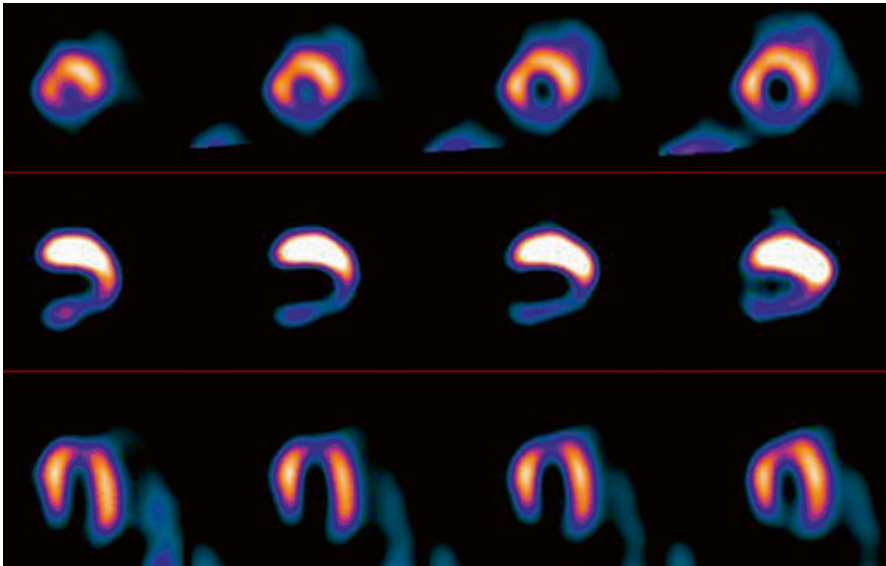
[^{123}I]-MIBG SPECT in a 43-year-old male HD patient. Note the low activity within the inferior left ventricular wall. Low [^{123}I]-MIBG inferior wall uptake that is often seen in SPECT can be an effect of predominant parasympathetic innervation in this part of the heart. Furthermore, the low uptake in the apex can be partially due to volume effect and also to an imbalance of sympathetic and parasympathetic nerves (Scott and Kench 2004; Flotas et al. 2010; Estorch et al. 2000). In addition, the interpretation of [^{123}I]-MIBG myocardial SPECT can be difficult, especially in patients on peritoneal dialysis who show an elevated position of the diaphragm
